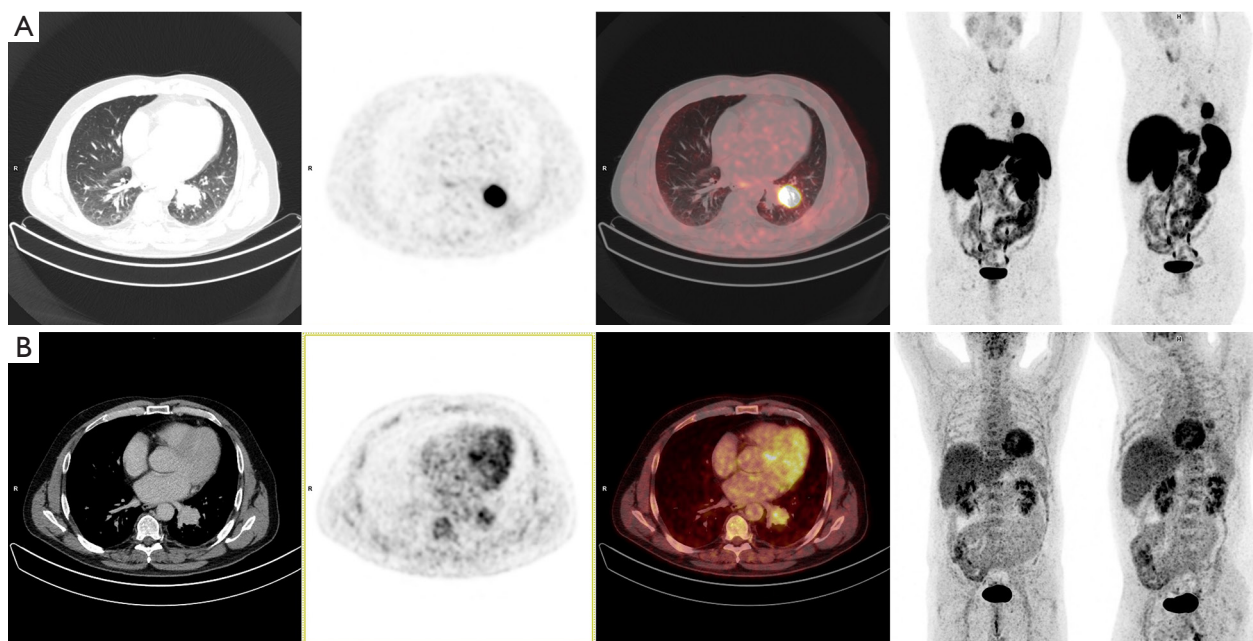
Preoperative PET/CT imaging. (A) Gallium-68-Edotreotide [^{68}Ga]-DOTATOC PET/CT. (B) [^{18}F]-FDG-PET/CT. To improve visualization of the FDG uptake of the carcinoid located dorsally of the heart, maximum intensity projections (MIP) are shown in anterior and left anterior oblique views. PET/CT, positron emission tomography-computed tomography; [^{68}Ga]-DOTATOC, Gallium-68-Edotreotide; [^{18}F]-FDG, fluorine-18-fluorodeoxyglucose.
